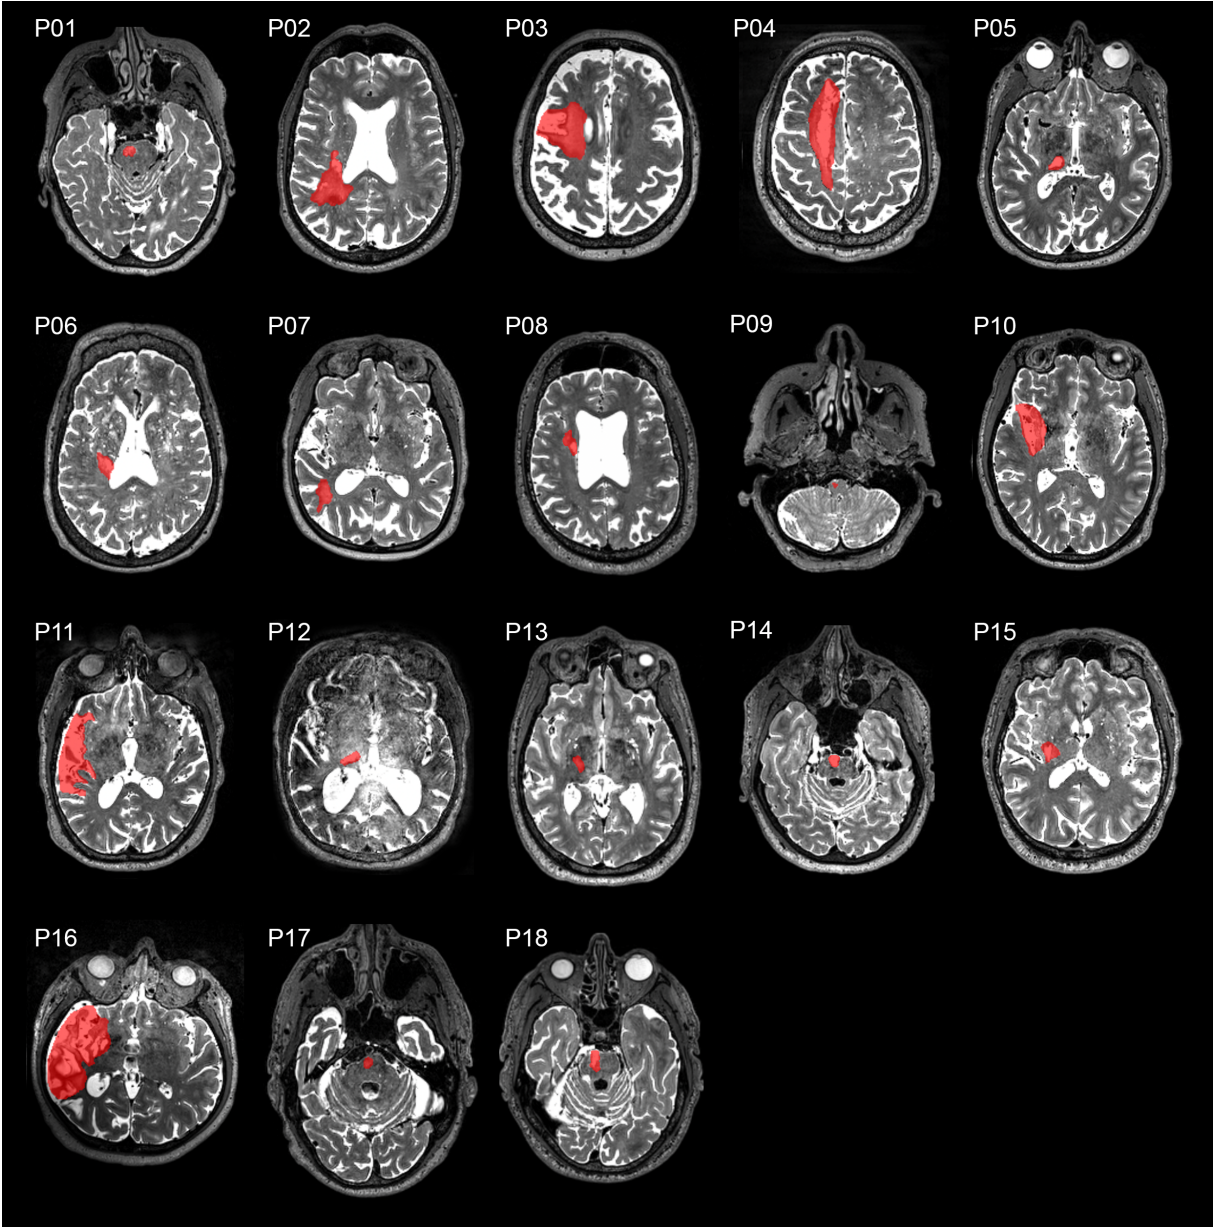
Individual patients' stroke lesion maps displayed in T2-weighted MRI images. All images were flipped along the midsagittal plane, so that lesions are commonly displayed on the left.
